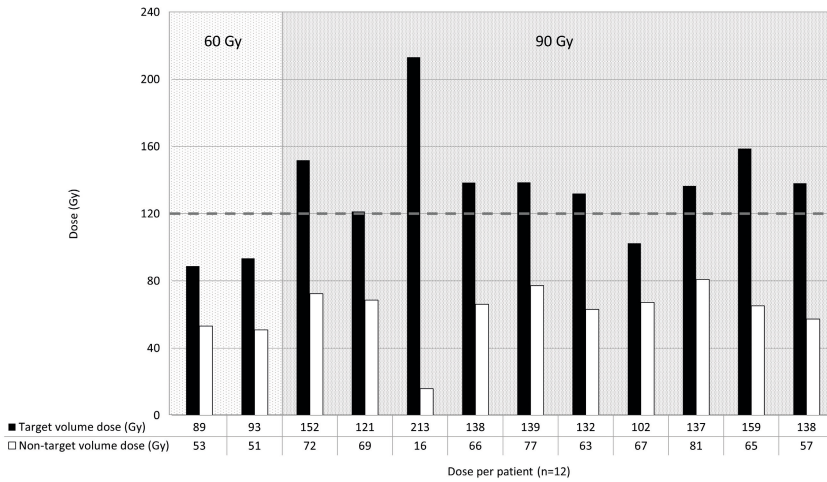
Dose distribution per patient within treatment volume, based on SPECT imaging. The bars in black represent the mean absorbed dose on the target volume directly surrounding the ablation volume per patient. The cut-off point of an absorbed target volume dose of ≥ 120 Gy is indicated by the horizontal dashed line. The bars in white show the absorbed dose to the non-target volume within the treatment volume. The first two patients were treated with 60 Gy to the treatment volume, whereas the other patients were treated with 90 Gy to the treatment volume. The median ratio of target volume dose vs non-target volume dose was 1.97 (IQR: [1.75 – 2.17]).
